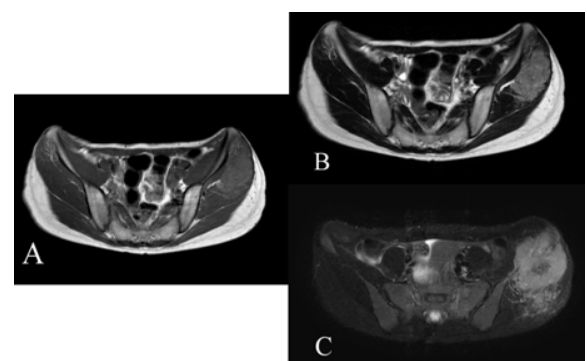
Axial T1-weighted MRI image revealing a higher signal intensity for the lesion than for the surrounding muscle in both intramedullary and extramedullary tumors (A). T2-weighted and STIR images indicating that most of the tumor showed high signal intensities and occasional spotty low intensities (flow voids) (B, C). Central portion in the lateral soft tissue mass showing low intensity on all three sequences indicative of tumor necrosis (A–C).
